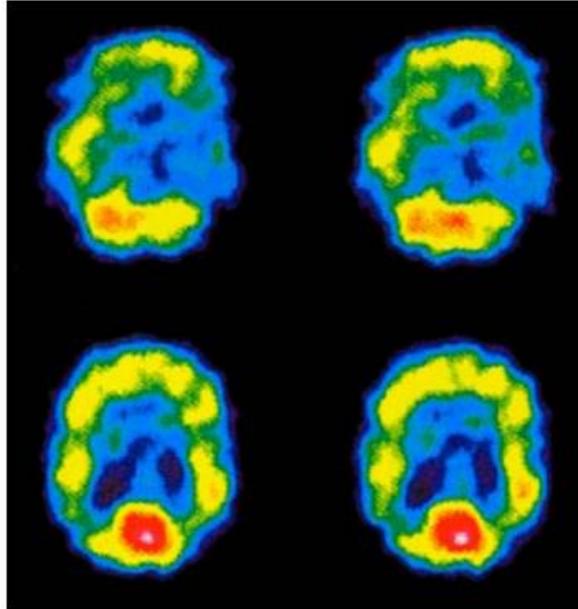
Image obtained with a SPECT scan
